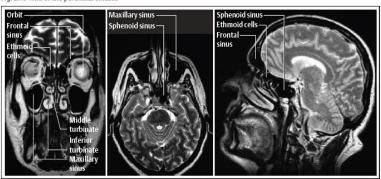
MRI of the paranasal sinuses
